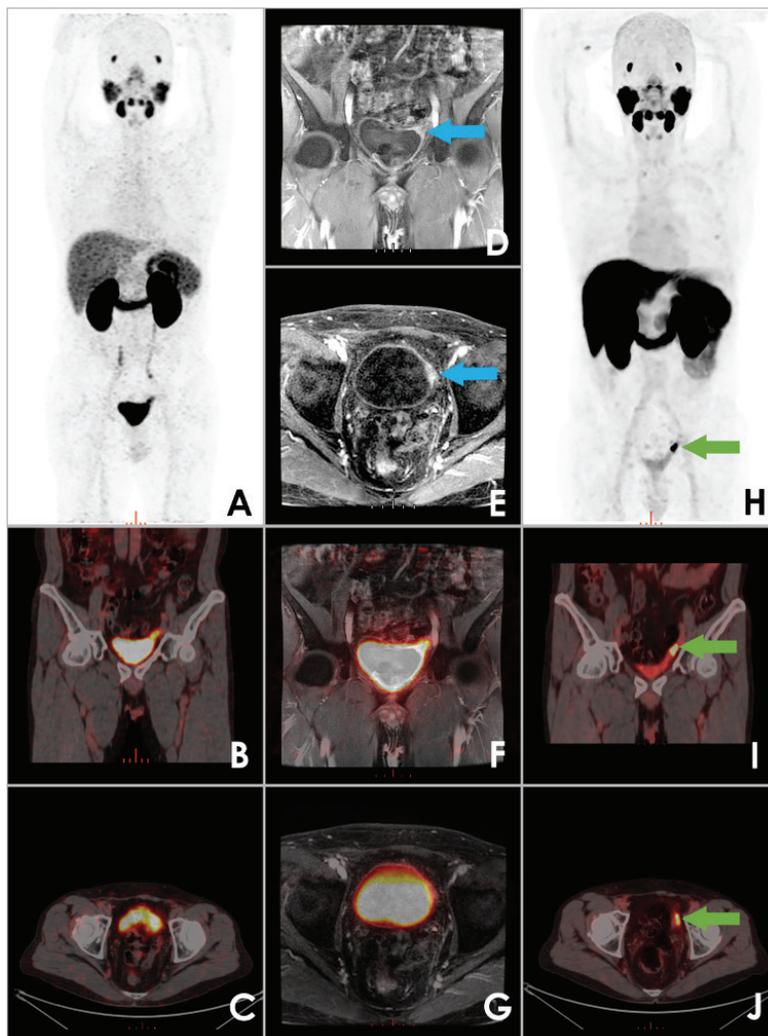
A 49-year-old man with a history of radical prostatectomy for prostate adenocarcinoma was referred for ^{68}Ga -prostate-specific membrane antigen (PSMA) positron emission tomography/computed tomography (PET/CT) because of increased levels of PSA as high as 0.52 ng/mL. There was no discernible pathological uptake on ^{68}Ga -PSMA PET/CT maximum intensity projection (MIP) (A), coronal (B), and axial (C) projections. After completing ^{68}Ga -PSMA whole-body PET/CT, pelvic PET/magnetic resonance imaging (MRI) with intravenous MRI contrast agent was performed to detect any local recurrence in the pelvis. In coronal (D) and axial (E) T1-weighted post-contrast MRI sequences, a lesion with contrast enhancement (blue arrows) was spotted on the left superior wall of the urinary bladder. However, in coronal (F) and axial (G) PET/MRI fusion images, no discernible uptake from radioactive urine could be detected. Three days later, the patient underwent a whole-body ^{18}F -PSMA PET/CT scan. Pathological uptake of ^{18}F -PSMA in the previously reported location in MRI scans has been observed (green arrows) in MIP (H), coronal (I), and axial (J) projections. In ^{18}F -PSMA PET/CT scans, there was a significant difference between activities detected in lesion and radioactive urine, unlike ^{68}Ga -PSMA PET scans. Prostate cancer is one of the most prevalent cancers in men worldwide (1). PSMA is a transmembrane protein that is highly expressed in prostate cancer cells (2). Its expression is increased in cases of more aggressive and dedifferentiated tumors (3). With the utilization of ^{68}Ga or ^{18}F labeled PSMA ligands, prostate cancer lesions can be imaged with positron emission tomography (4,5). Although ^{18}F -PSMA-1007 and ^{68}Ga -PSMA-11 are both PSMA ligands that can be used for imaging prostate cancer, there are some differences in their biodistribution and excretion mechanisms. Urinary extraction of ^{18}F -PSMA-1007 is minimal (5), unlike ^{68}Ga -PSMA-11, which can be an advantage in detecting local recurrences due to close proximity of the prostate gland and urinary bladder.
